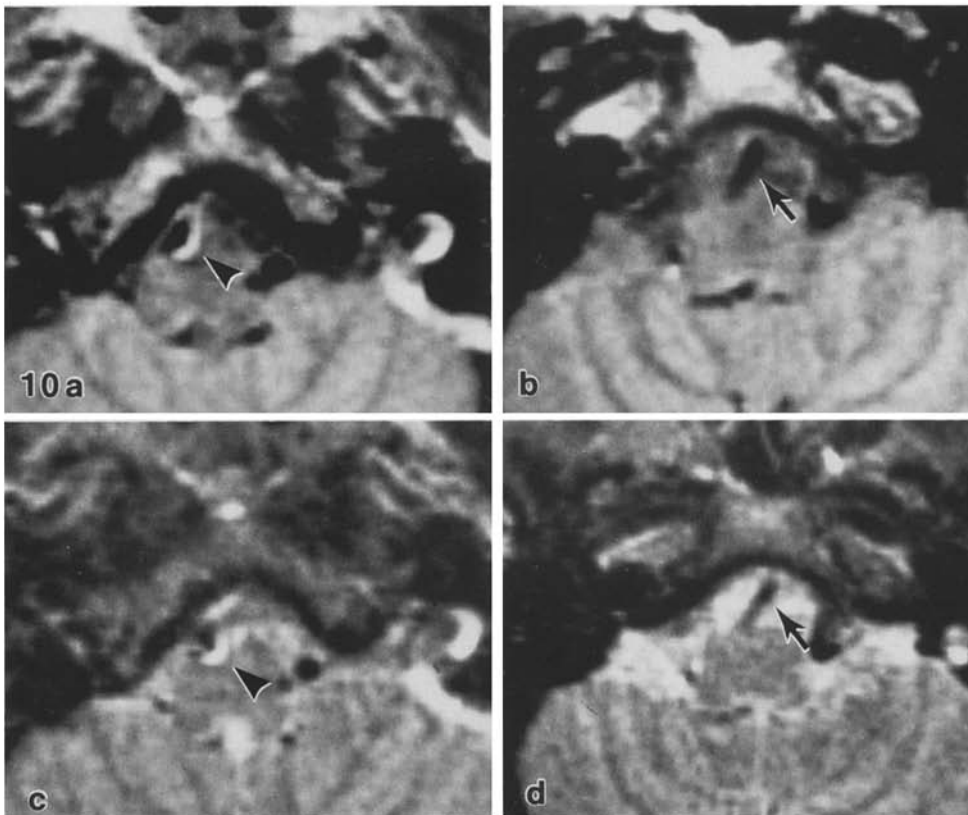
a-d. Case 5. PD-weighted (a, b) and T2-weighted (c, d) axial images showing a dilatation of the right vertebral artery (b, d, arrows). Arcuate hyperintensities on the medial part of the right vertebral artery (a, c, arrowheads) are thought to be misregistered flow-related enhancements (see text)
